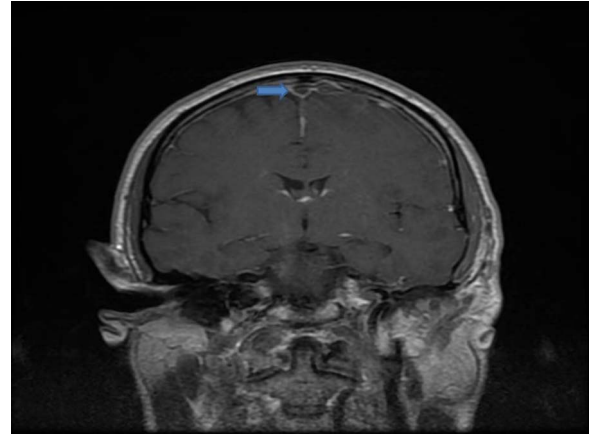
Coronal postcontrast T1-weighted image showing expansile continuous filling defect dominating superior sagittal sinus with left frontal cortical and subcortical acute oedema.
